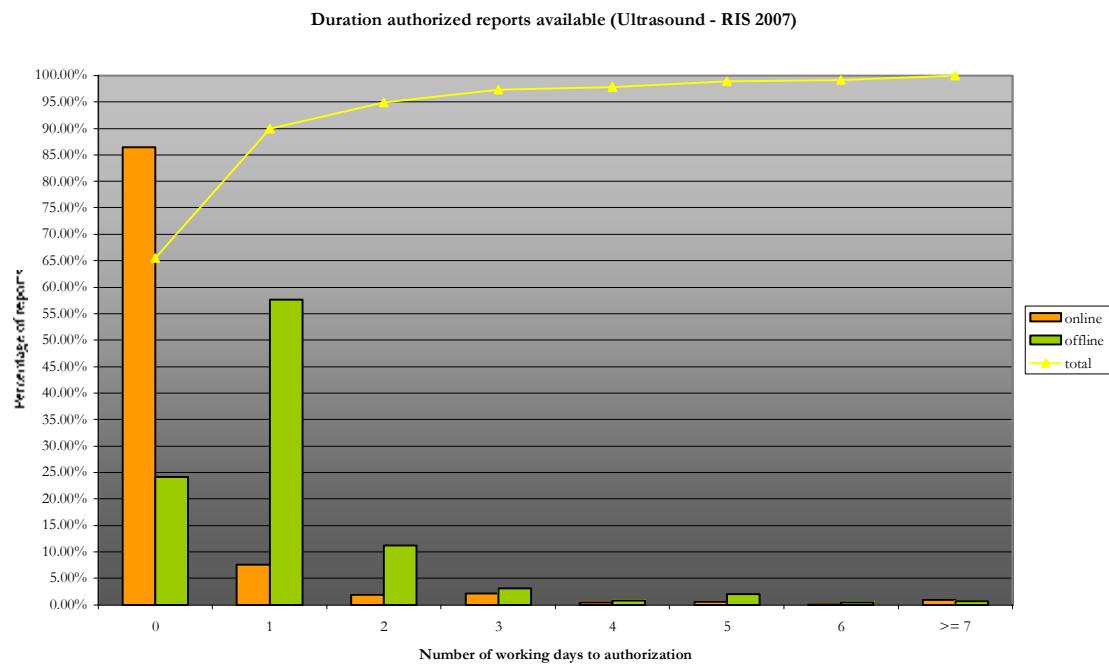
Throughput time radiology report Ultrasound: online versus offline (RIS 2007)
